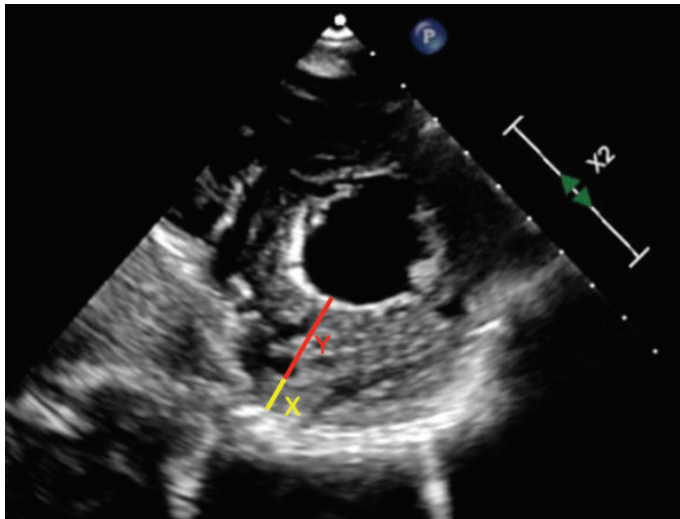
Chin criterion with transthoracic echocardiography: X (yellow line) / Y (red line) ≤ 0.5 in the short-axis view at end-diastole.
